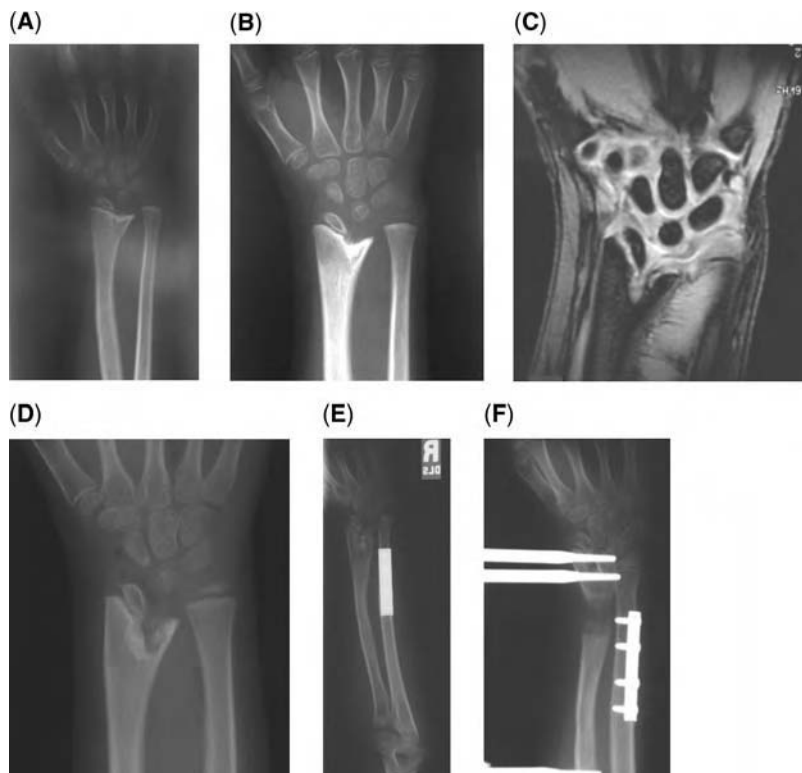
A four-year-old female with a Salter Harris type IV fracture of the right distal radius. Plain films at the time of diagnosis showed the fracture. (A) The fracture was treated with a short arm cast for five weeks. Follow-up films seven months after initial injury show a possible Type I peripheral growth arrest. (B) An MRI was obtained, which demonstrates growth failure and extension of the physeal cartilage into the metaphysis without an obvious bone bridge. (C) X rays taken immediately after physeal bar resection and fat graft interposition show satisfactory resection (D), but growth did not resume. X-rays taken after the second attempted bar resection and fat graft interposition. Ulnar shortening and radial osteotomy was done. (E) Growth did not resume and the patient was treated with a radial lengthening (F), and the plan is to do future lengthenings.
